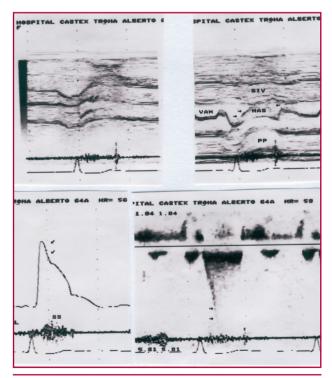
Sixty-four year-old patient with obstructive hypertrophic cardiomyopathy. *Left* (Upper panel): M-mode ultrasound showing sclerotic aortic valve with reduced opening, without gradient by Doppler ultrasound; (Lower panel): Carotid pulse recording with rapid upstroke and early collapse due to the subaortic obstruction. *Right* (Upper panel): M-mode recording of the systolic anterior motion of the mitral valve; (Lower panel): telesystolic subaortic gradient.
